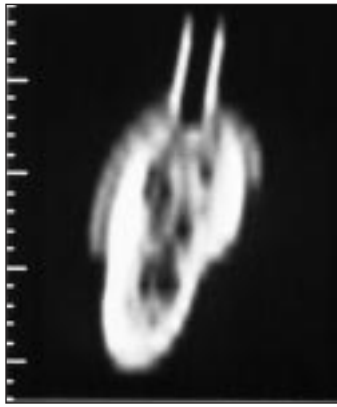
Dental CT^R image of a dried mandible.
